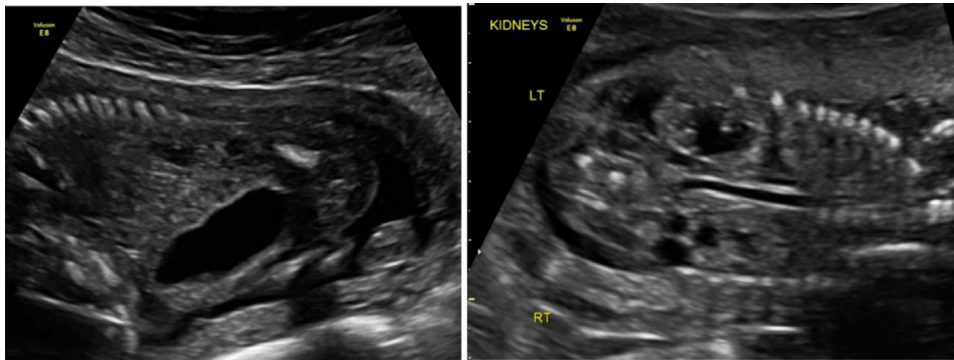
Case 1. Prenatal ultrasounds at 17 weeks' gestation. (A) Large dilated cystic structure in the abdomen deforming the anterior abdominal wall. Presence of calcifications in the recto-sigmoid colon. (B) Moderate bilateral hydronephrosis. Cysts are identified in the kidneys bilaterally with perinephric fluid bilaterally that suggests calyceal rupture. Oligohydramnios.
